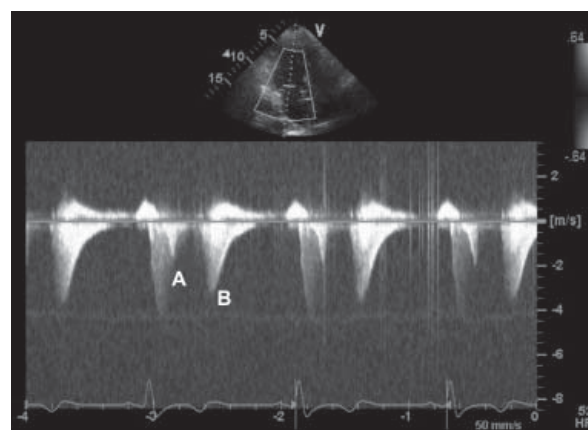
Echocardiographic and continuous-wave Doppler images at the obstructive apical ring show a short interval of early systolic blood flow (A), which was interrupted for most of systole and followed by a higher blood-flow velocity peak in early diastole (B), at the time of the delayed diastolic relaxation. See also Figure 3. Therefore, the intraventricular systolic gradient did not seem to be caused by blood flow, but rather by systolic contraction of the obstructive ring in the presence of systolic obliteration of the apical cavity.
